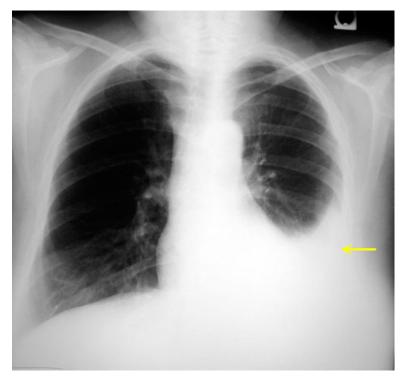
Pleurisy with effusion X-ray examination This image was downloaded from website https://www.meddean.luc.edu
